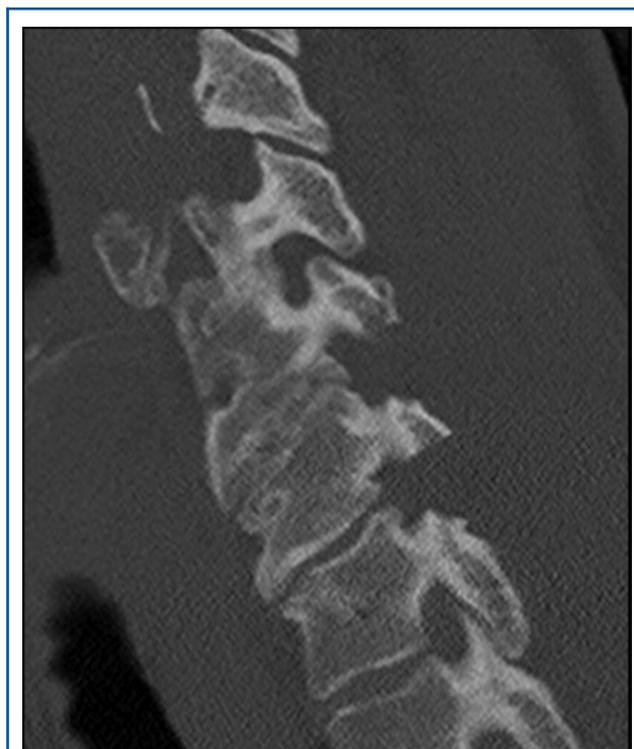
Parasagittal CT of the cervical spine after 2-level foraminotomies showing the unroofing of the foramina with the bone removal reaching the pedicles rostral and caudal to the exiting root.*
